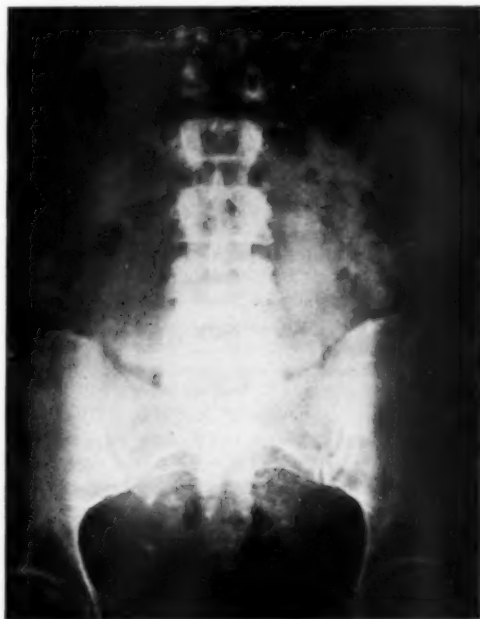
Anteroposterior roentgenogram of abdomen demonstrating enlarged uterine shadow. The fetus is in a horizontal position, overlying the lower sacrum.
